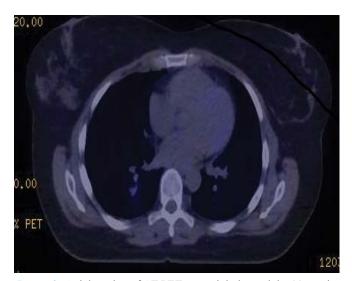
Axial section of CT PET scan; right lower lobe 11 mm in size lung lesion shows low degree of Dotatate activity.
